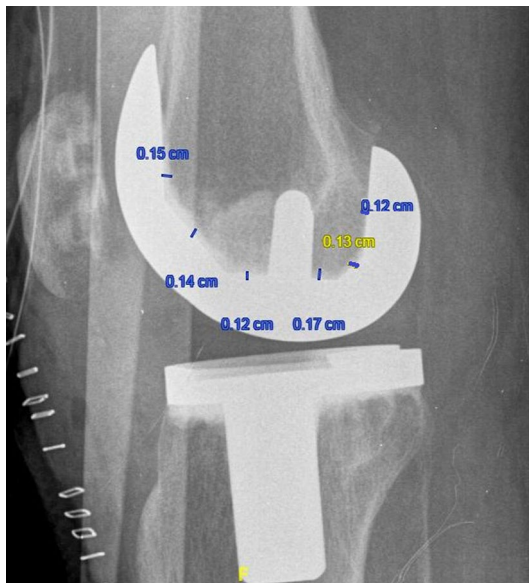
Radiographic measurement of the cement bone intrusion in the femur in six areas: anterior cut, anterior chamfer cut, two in the distal cut, posterior chamfer and posterior cut
